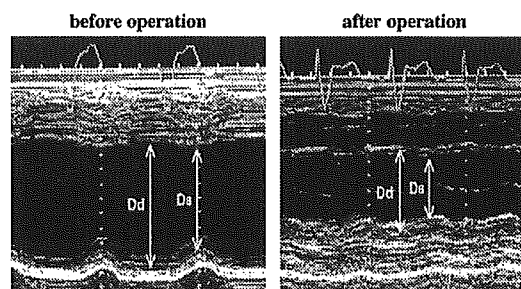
M-mode echocardiography performed before (Left) and 1 month after (Right) partial ventriculectomy. The end-diastolic dimension of the systemic ventricle decreased from 8.6 cm to 5.7 cm, but the calculated fractional shortening did not change. After the operation, an echo-free space, suspected to be a hemorrhagic pericardial effusion, and thickened pericardium were seen behind the systemic ventricle.
